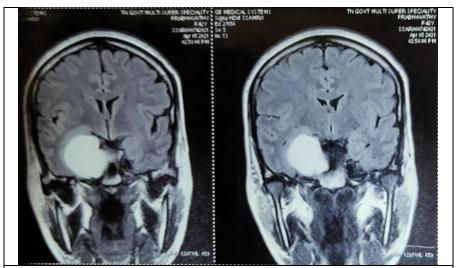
MRI image of a 42 years of female showing right cavernous hemangioma with right sided oculomotor nerve palsy
